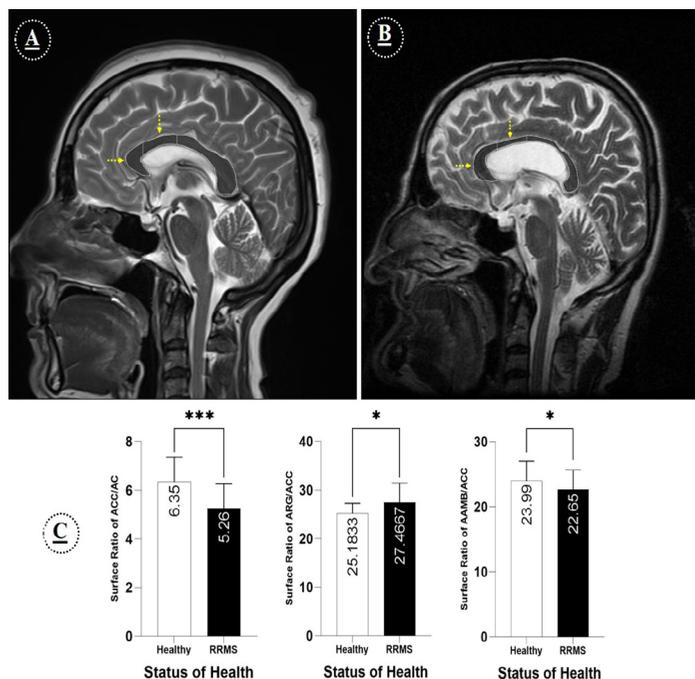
A: Brain MRI image in midsagittal section in a healthy individual
